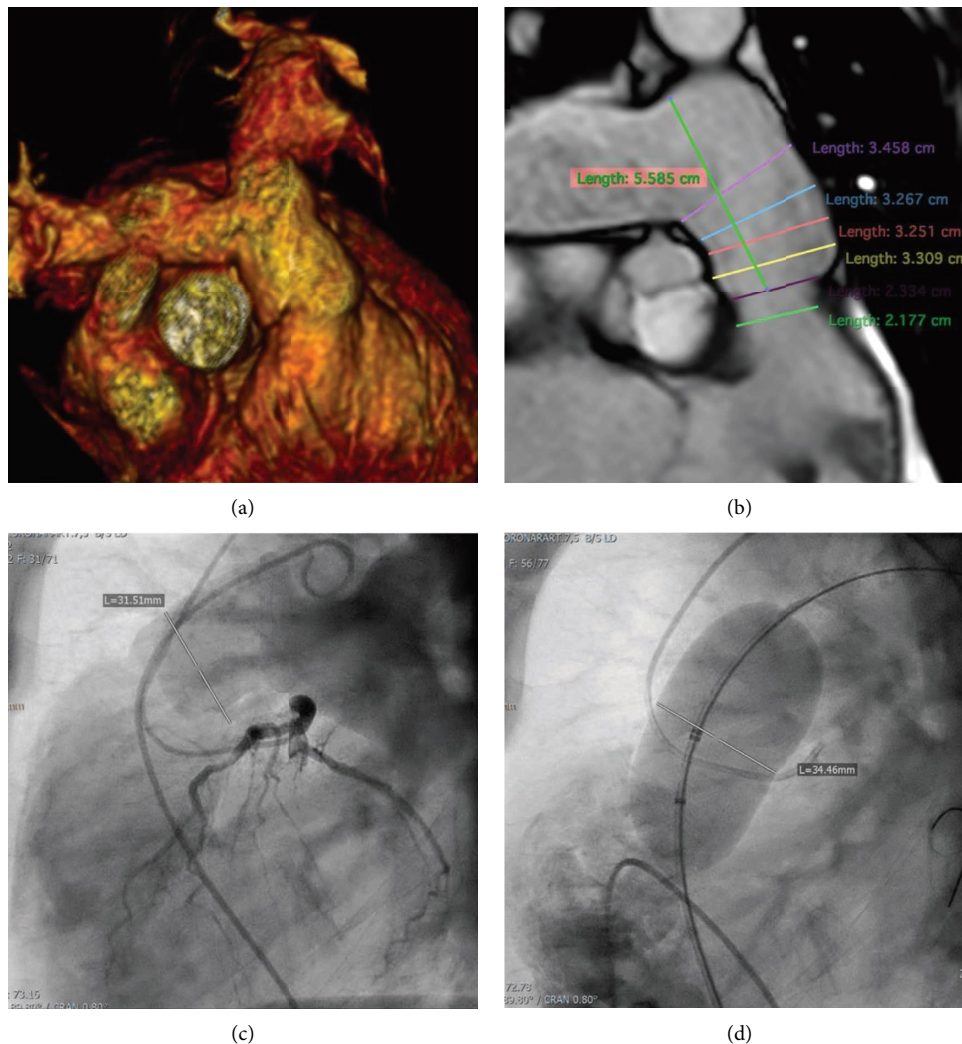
Preprocedural imaging and measurements in a patient with subsequent Venus P-Valve™ implantation. 3D reconstruction (a) and assessment of RVOT dimensions (b) from preprocedural MRI. (c) Angiography of the pulmonary artery/RVOT with simultaneous coronary angiogram of the left coronary artery. (d) Balloon sizing of the RVOT with simultaneous RV angiogram demonstrating complete occlusion. MRI: magnetic resonance imaging; RV: right ventricle; RVOT: right ventricular outflow tract.
